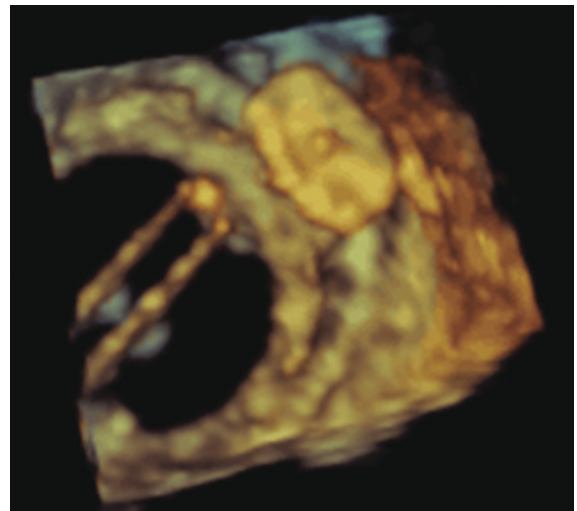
Three-dimensional transesophageal echocardiogram of a mitral mechanical bileaflet valve following transapical paravalvular leak closure. An Amplatzer vascular plug has been implanted at approximately the 2 o'clock position relative to the valve sewing ring.
